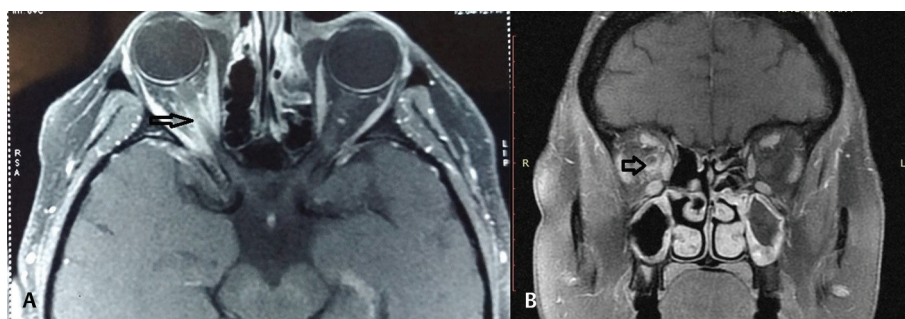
Contrast-enhanced magnetic resonance imaging brain with orbits (T1-weighted image) axial section (A) showing ill-defined homogeneously enhancing area noted in the right orbital apex. “Tram track” enhancement (arrow) of the optic nerve sheath in the axial section and “doughnut-”shaped enhancement (arrow) in the coronal section (B) can be noted.
